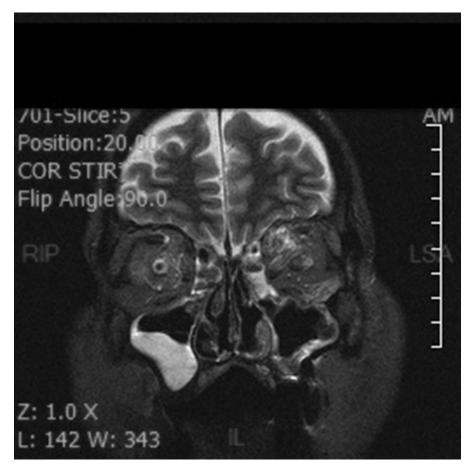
Enhancement of retrobulbar tissues including superior ophthalmic vein as evident in CST, seen on MRI. Horowitz et al. Cavernous Sinus Thrombosis. J Oral Maxillofac Surg 2013.
